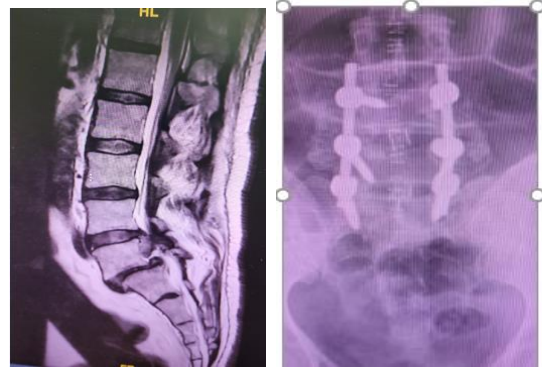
46 ys male with L5-S1 spondylolisthesis with L4-5 adjacent level disc disease and caudal disc migration (preoperative MRI and postoperative x-ray)
